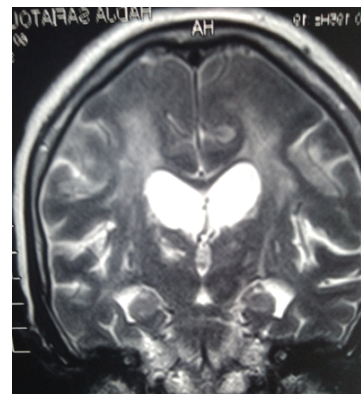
Coronal slice MRI T2 sequence: Confluent periventricular hypersignals extending into the SBs
